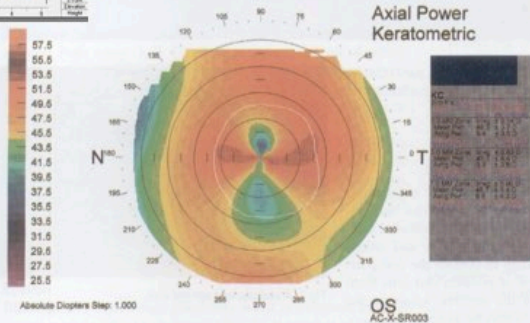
Corneal contour chart produced by computed tomography.
